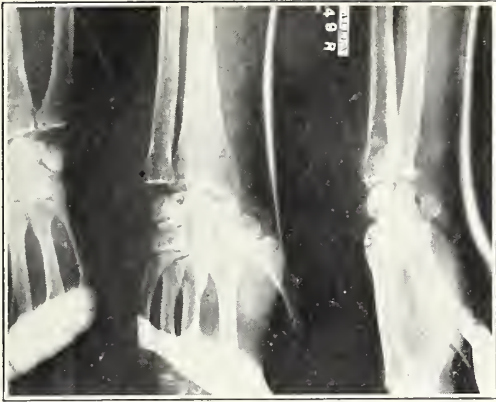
Roentgenogram showing a fracture of the scaphoid with osteoporosis of the semilunar and cuneiform.
